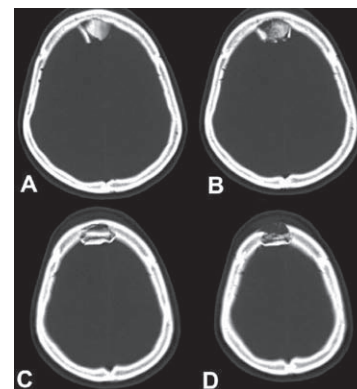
CT scan brain (bone window) showing midline frontal depressed fracture
